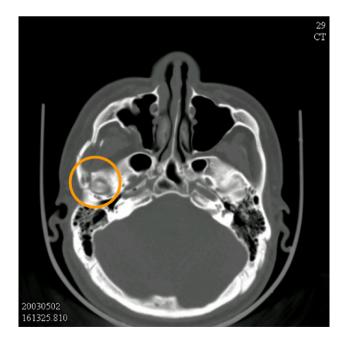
CT images showing a ZMC fracture line involving the articular eminence of the temporomandibular joint (TMJ). The encircled areas indicate the fracture site.
